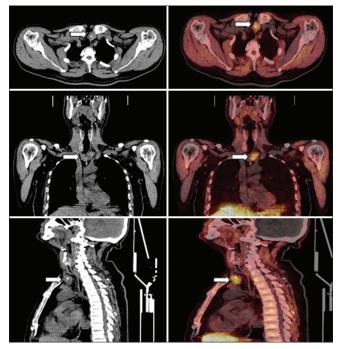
¹⁸F-FCH PET/CT of a 65-year-old male with recurrent primary hyperparathyroidism demonstrating intensely FCH avid lesion (white arrow) with internal calcification in the inferior pole of the erstwhile left thyroid lobe seen in axial, coronal, and sagittal sections. PET/CT: Positron emission tomography/computed tomography
